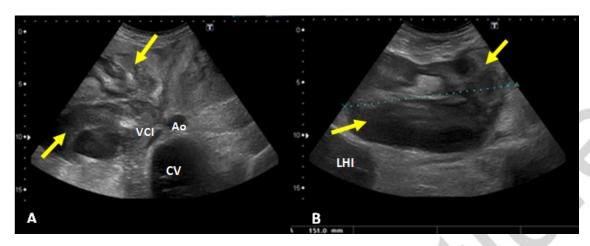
Abdominal ultrasound (transverse section) showing a heterogeneous hypoechoic mass which is located next to different structures: inferior vena cava (VCI), abdominal aorta (Ao) and vertebral body (CV). B. The mass measures 15 centimeters (yellow arrows) and compresses the left hepatic lobe (LHI) and the pancreas.
